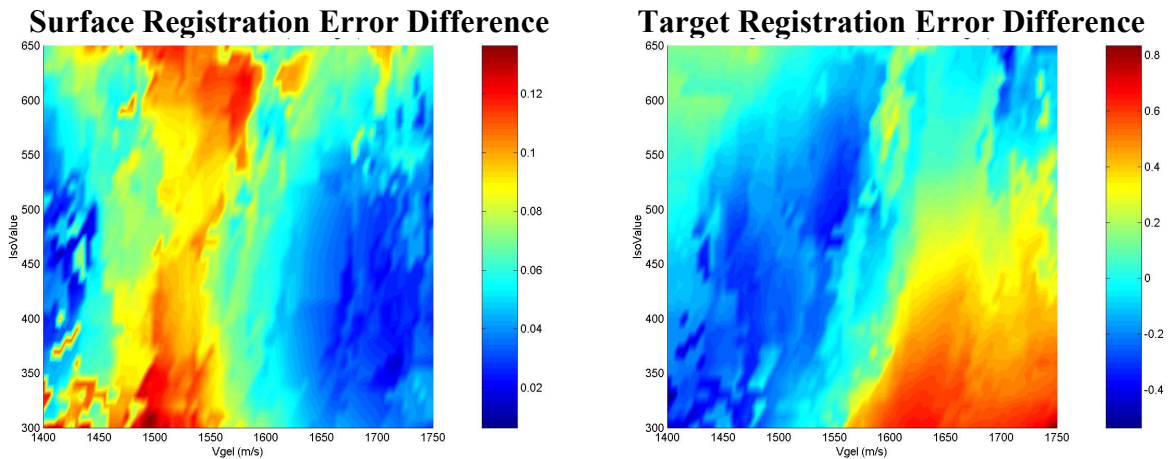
Differences in the registration errors between Model B (based on the original CT volume) and Model E (based on the CT4 volume). (a) surface registration error difference between a model created from 2 mm slices and a model created from 4mm slices vs. isointensity parameter and speed of sound in gelatin, (b) target registration error difference vs. isointensity parameter and speed of sound in gelatin. All registration errors have units of mm.
